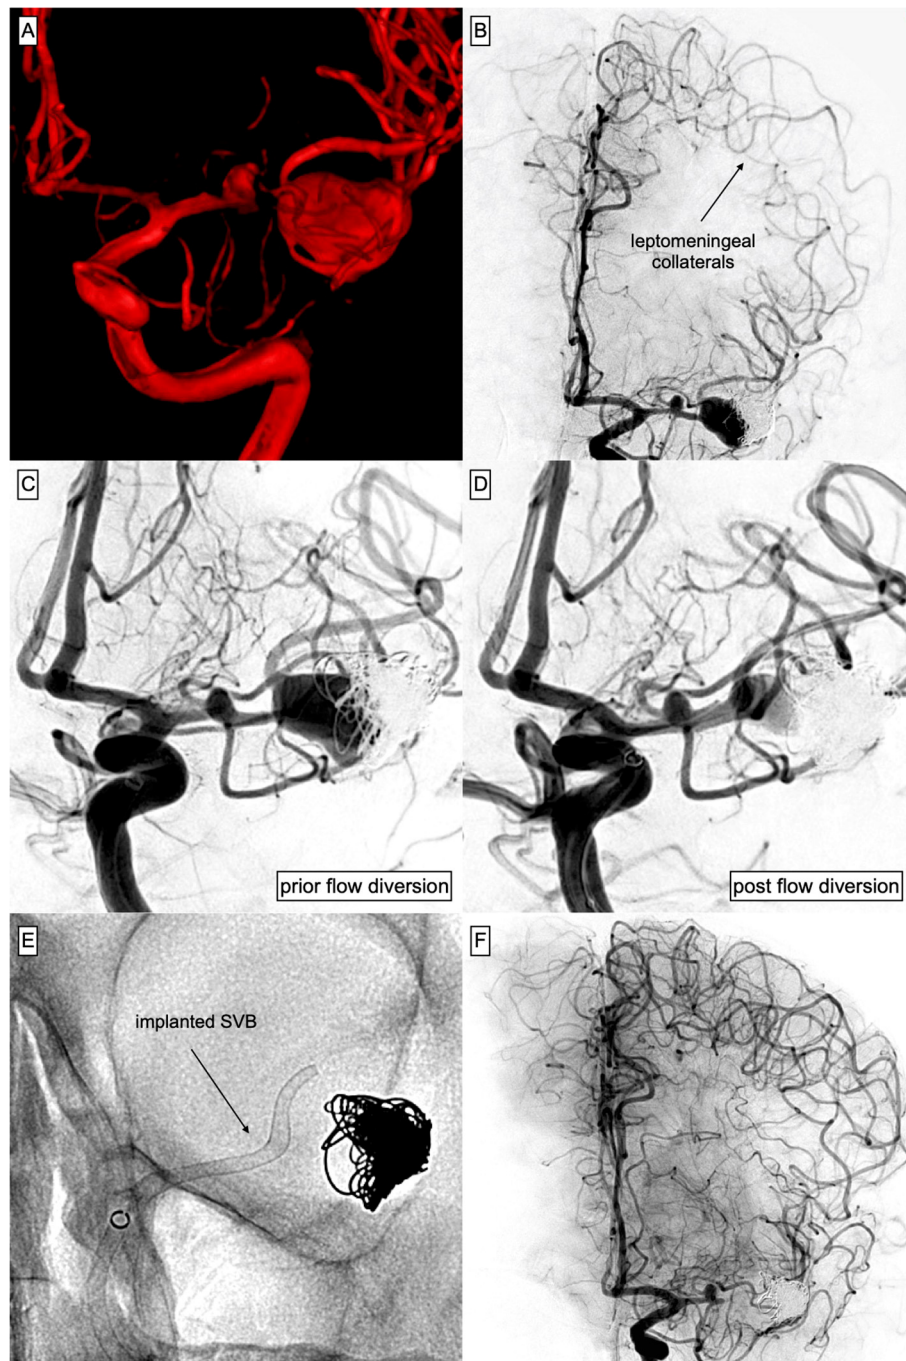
Complex course of a ruptured aneurysm arising from the MCA-bifurcation, treated with Plug & Pipe. (A) 3D reconstruction of the acutely ruptured, complex MCA-bifurcation aneurysm measuring 10 mm × 18 mm. (B) DSA 3 weeks after protective coiling of the ruptured aneurysm aiming for fundus protection and preservation of the bifurcation. Note the distinct ACA–MCA collaterals that had developed with SAH-associated subacute vasospasm. (C) Aneurysm after coiling, prior TO SVB implantation. Also note the coincidental aneurysm arising from the M1 segment and the stenosis preceding the aneurysmal orifice. (D) Control injection after implantation of the SVB [(E) shows the corresponding radiograph] into the MCA. The device covers the proximal M1 aneurysm and extends into the superior branch of the bifurcation, significantly reducing aneurysmal inflow. (E) Non-enhanced radiograph corresponding to (D). (F) Three days after SVB implantation, the patient had developed a subtle right-sided facial paresis and fluctuating aphasia. Immediate DSA revealed no opacification of the distal MCA including the bifurcation-aneurysm but patency of the proximal SVB including the coincidental M1 aneurysm and a temporal MCA branch arising from the aneurysm base. However, ACA–MCA collaterals completely supplied the peripheral MCA territory distal to the occluded segment. A significant perfusion gradient between the proximal M1 segment and the stenotic pre-bifurcation segment had developed, which culminated in the manifestation of a distinct watershed zone after SVB implantation. Blood pressure was raised and the neurological deficit ceased subsequently. The patient had recovered completely after 48 h.
